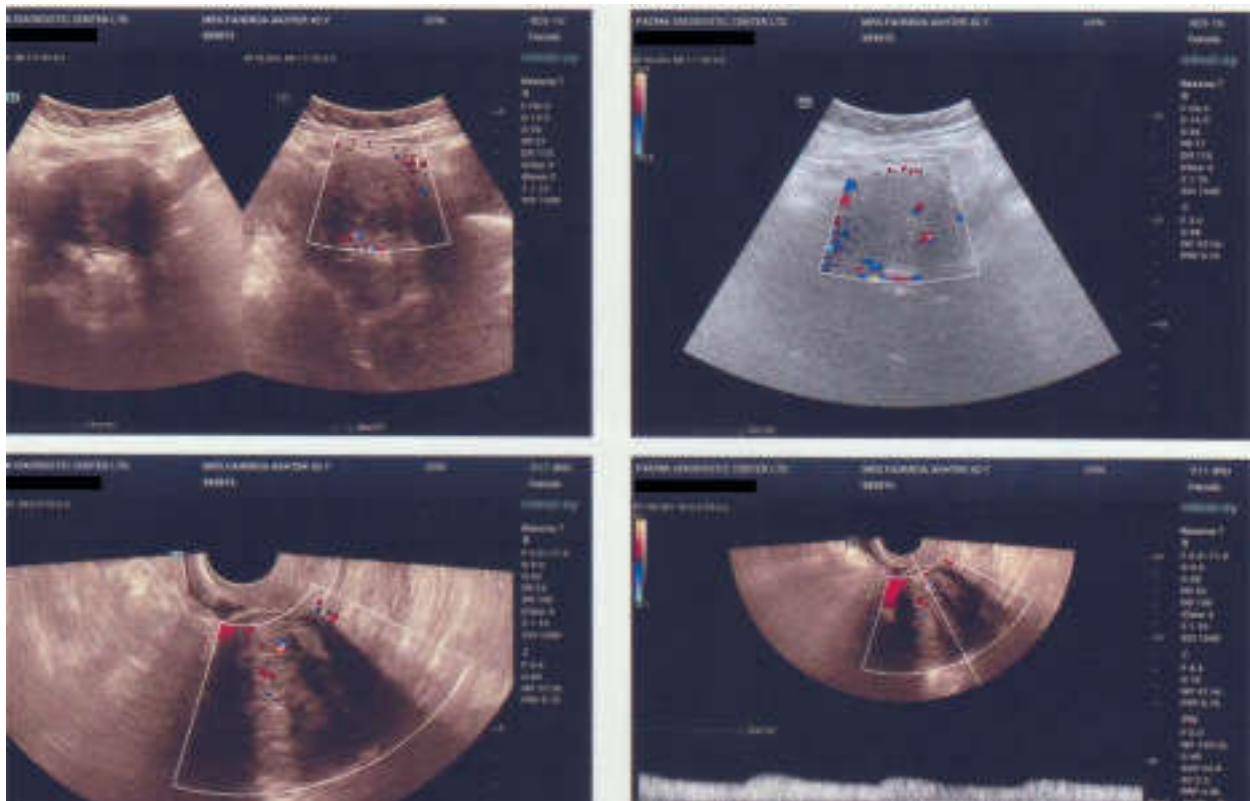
On color doppler the lesion shows peripheral vascularisation
